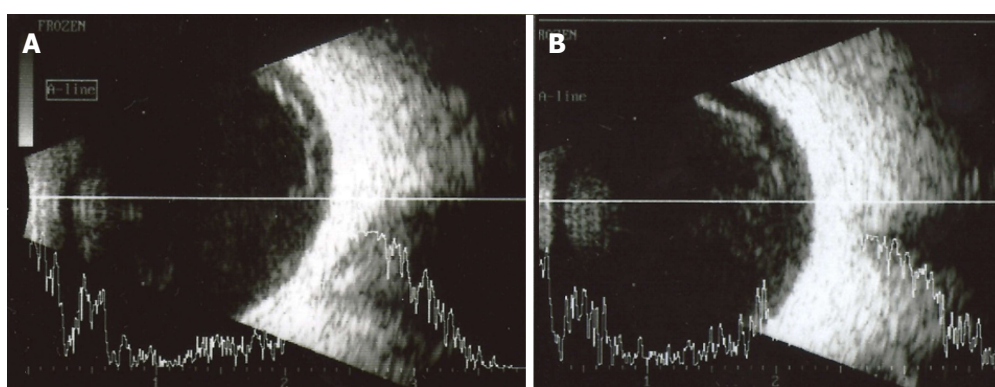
Ophthalmic ultrasound of right (A) and left (B) eyes showing some vitreous opacities corresponding to amyloid deposits in the vitreous. This amyloid deposition in the vitreous is relatively mild compared to the degree of amyloid deposition in anterior segment.
